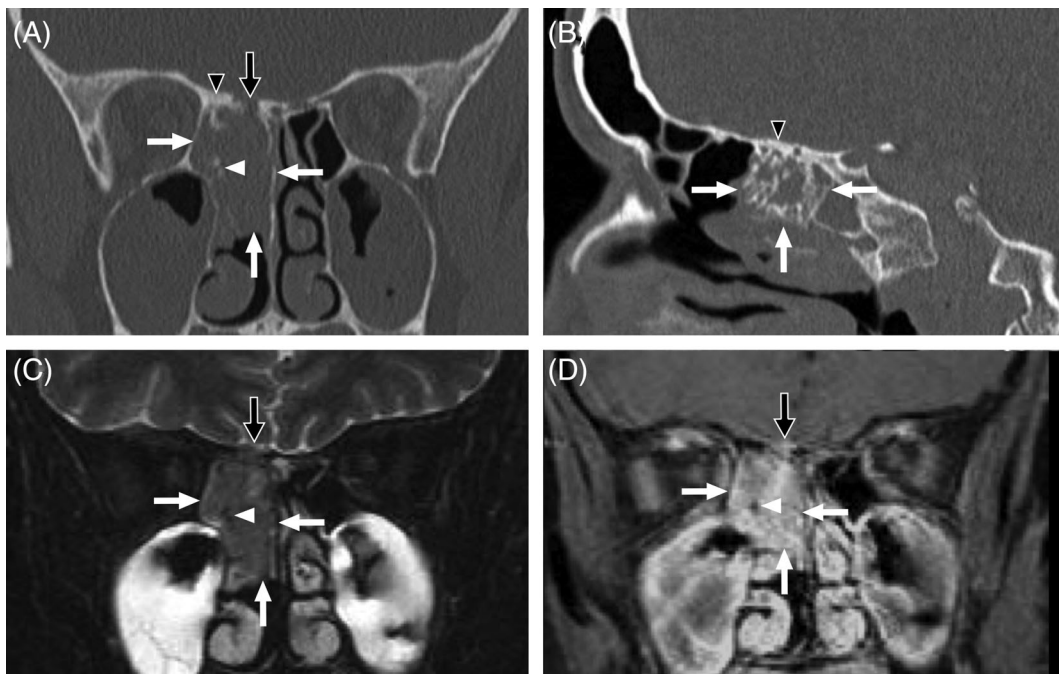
Imaging features of BSS in a 44 year-old woman. (A) Coronal noncontrast CT. (B) Sagittal noncontrast CT. (C) Coronal T2-weighted MRI with fat saturation. (D) Coronal contrast-enhanced T1-weighted MRI with fat saturation. A sizable tumor (white arrows) occupies the posterior right ethmoidal region and upper nasal cavity extending from nasal septum to right lamina papyracea. Although no orbital invasion is present, the anterior skull base, which is thickened secondary to hyperostosis (black arrowheads), demonstrates focal erosion (black arrows) with a small volume of extra-axial tumor invading the floor of the anterior cranial fossa. The tumor exhibits T2 signal characteristics that are similar to gray matter. The interspersed foci of hyperostosis appear dark on MRI pulse sequences (white arrowheads), which contributes to a pattern of heterogeneous enhancement.
